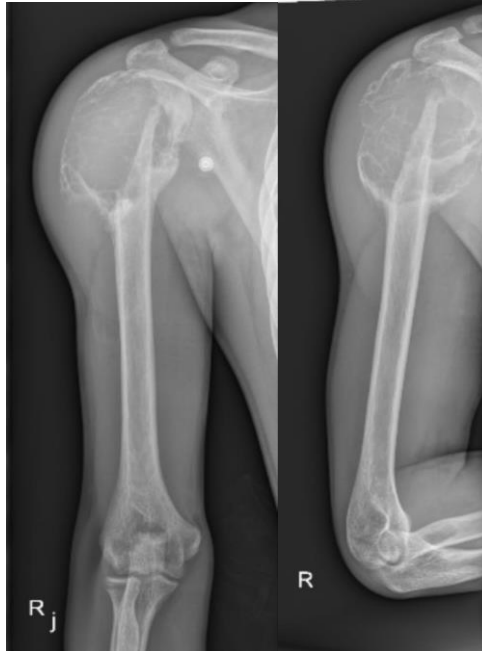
right humerus radiograph showing a massive bone tumor on the proximal of the humerus
